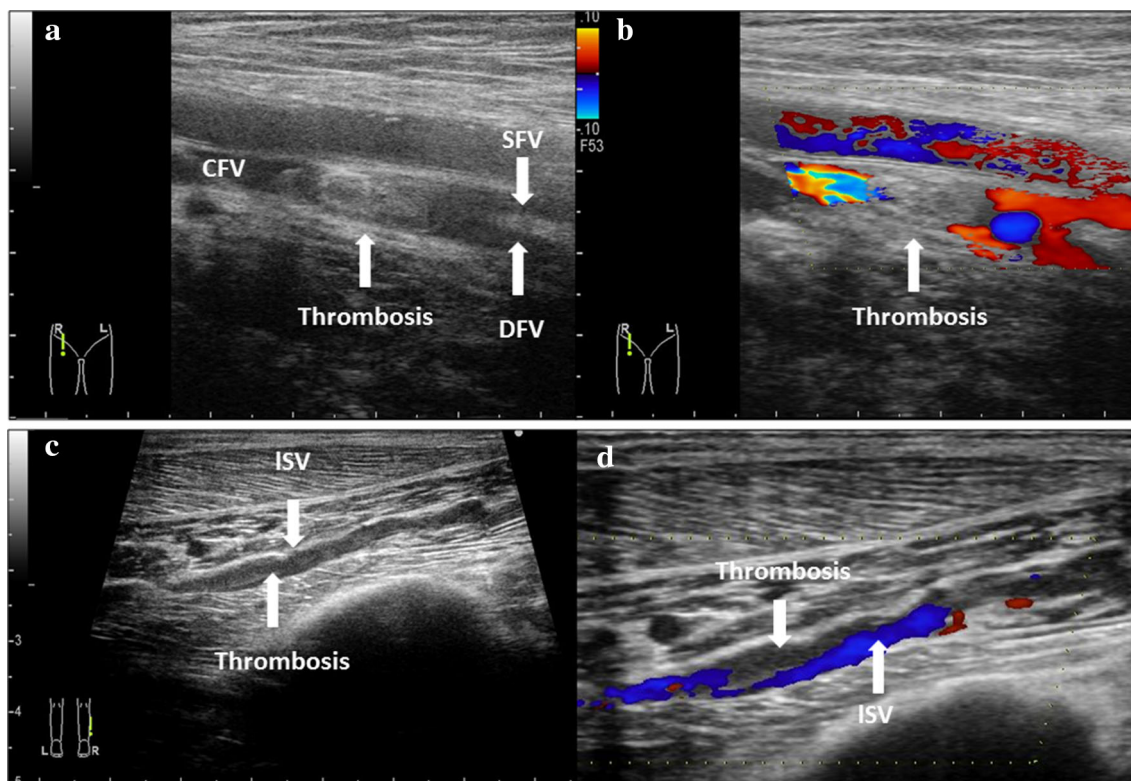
Ultrasonographic images of patients with deep venous thrombosis. B-mode imaging shows the lateral soleal vein of the right side (a, b) and the right common femoral vein (c, d). *CFV*
